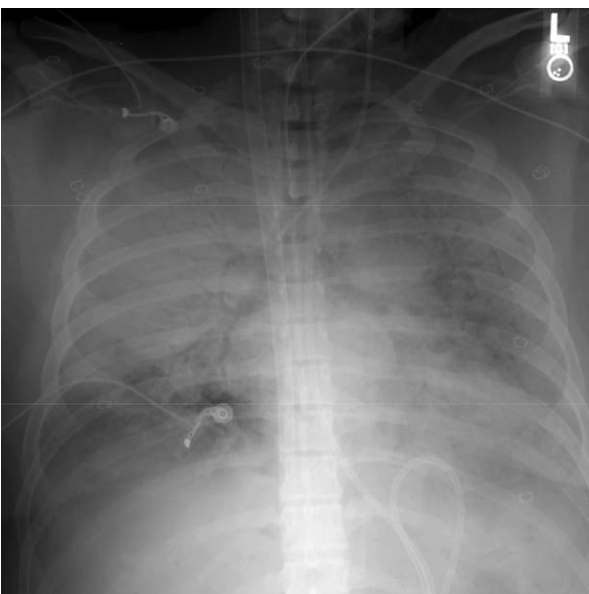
Chest radiograph on the day of extracorporeal life support initiation.
